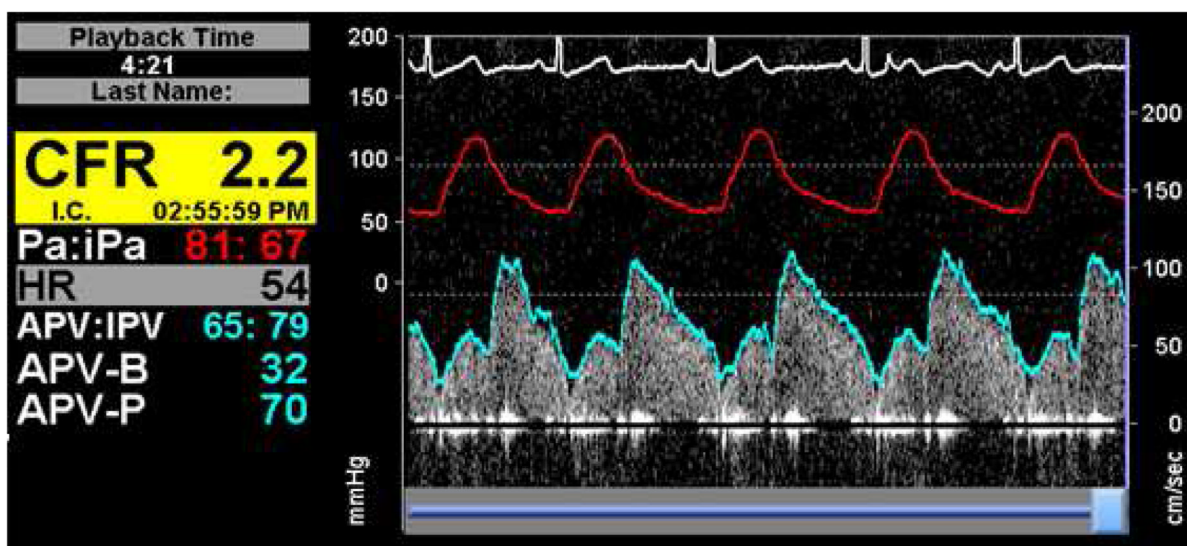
Intracoronary Doppler blood flow velocity waveforms before intracoronary adenosine (A), and after intracoronary adenosine infusion (B). CFR is the ratio of average peak velocities before and after adenosine.
